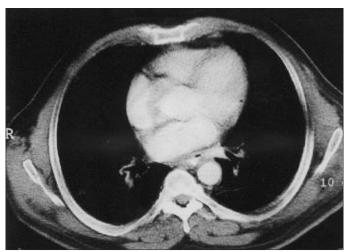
CT examination is quite normal after six cure of chemotherapy
